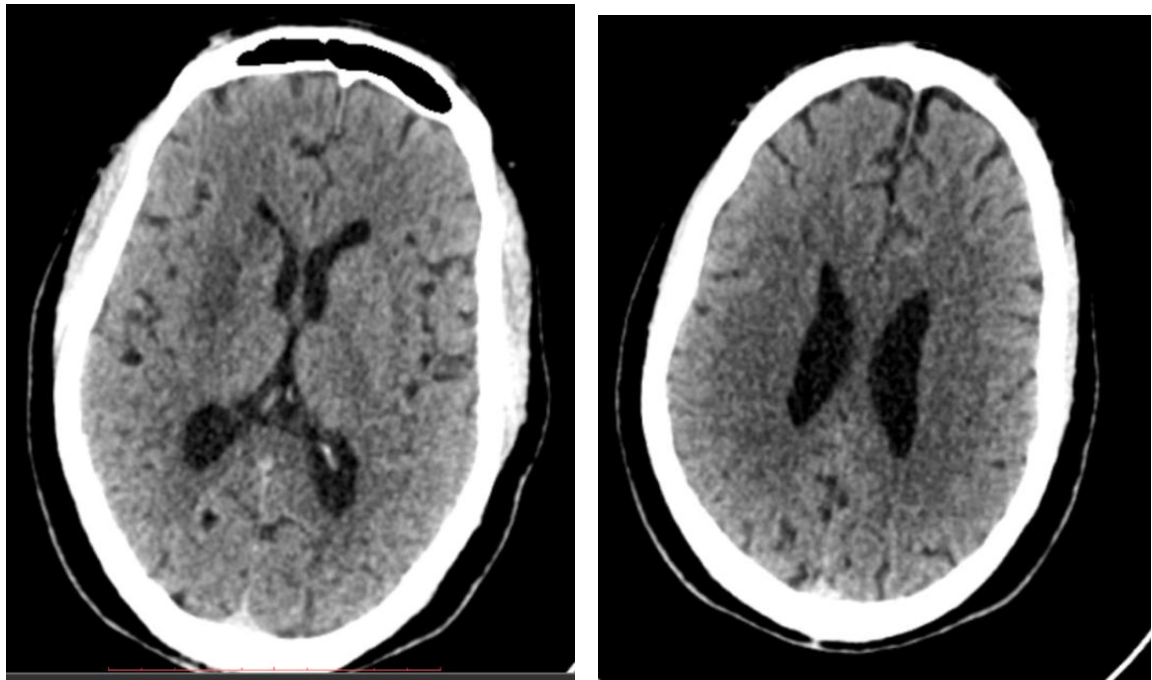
Axial non-enhanced CT brain of a 45 year old male showing acute infarct of the right lentiform and caudate. Estimated time to imaging was 30 hours.
